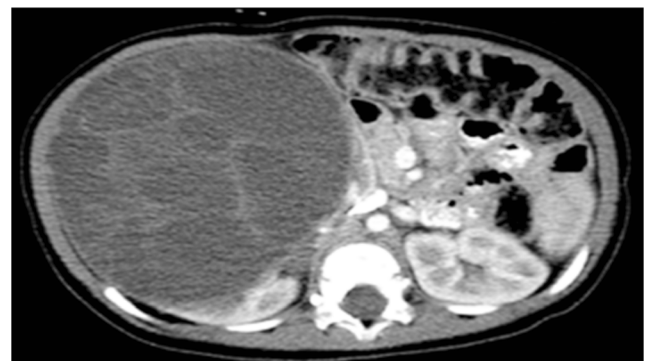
Axial abdominal contrast-enhanced CT image of a large right septated cystic renal mass (cracked windshield sign) in a 14-month-old boy (patient 2) was pathologically confirmed to be cystic nephroma, with imaging morphology classified as Is – a septated cyst
